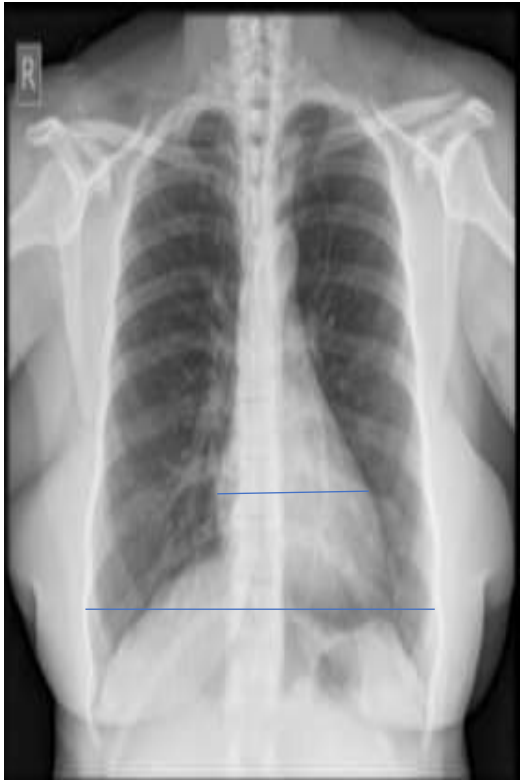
Shows the normal chest x-ray with CTR -0.43 (Non Smoker)
